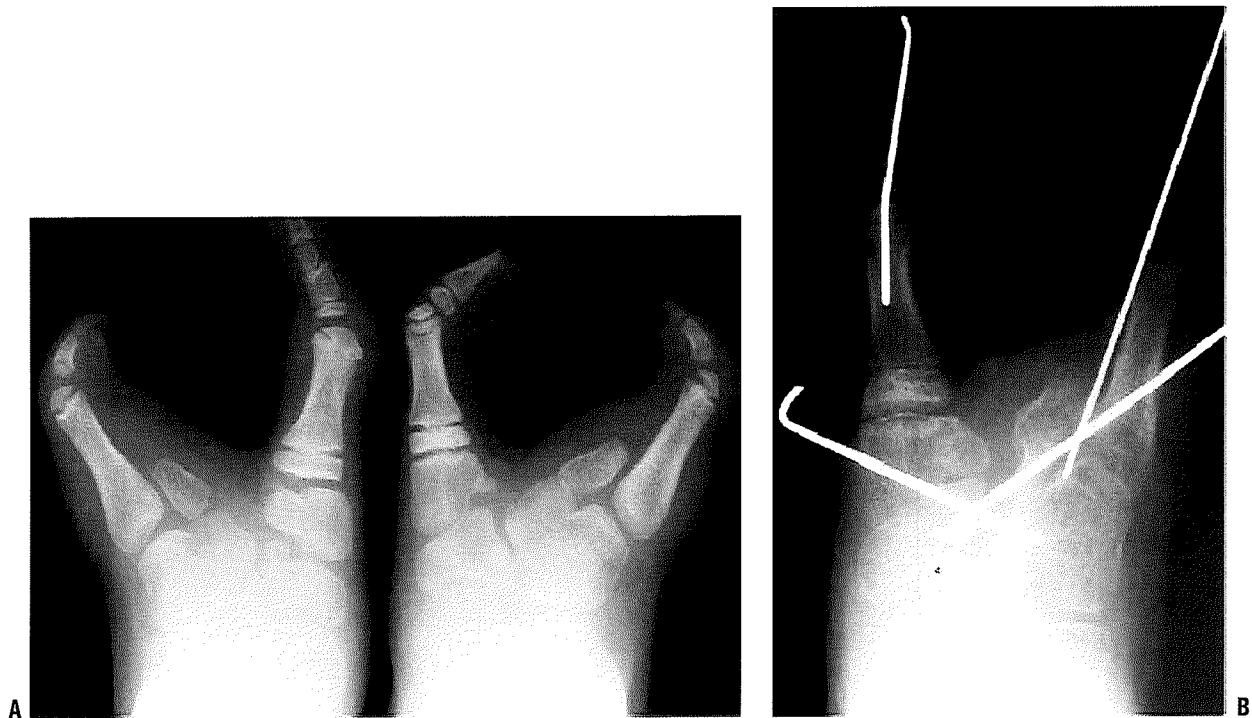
Preoperative (A) and postoperative (B) radiographs of symptomatic cleft foot treated with osteotomies. (From the private collection of Vincent S. Mosca, MD.)
